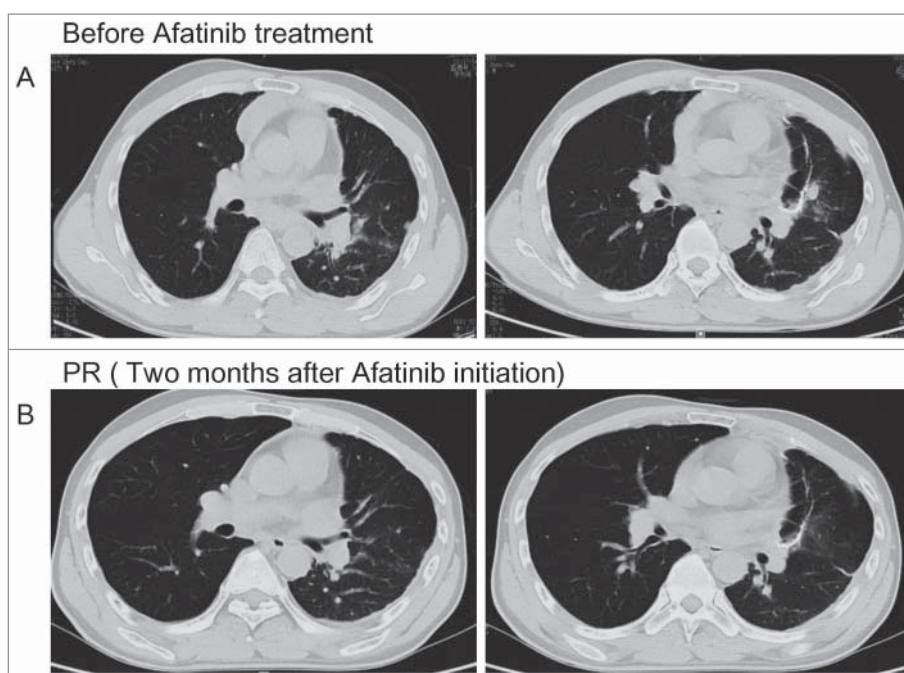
Chest computed tomography scan revealed the tumor response to afatinib. (A) The progressive disease status of lung lesion before afatinib treatment. (B) The partial response of lung lesions after afatinib treatment.
